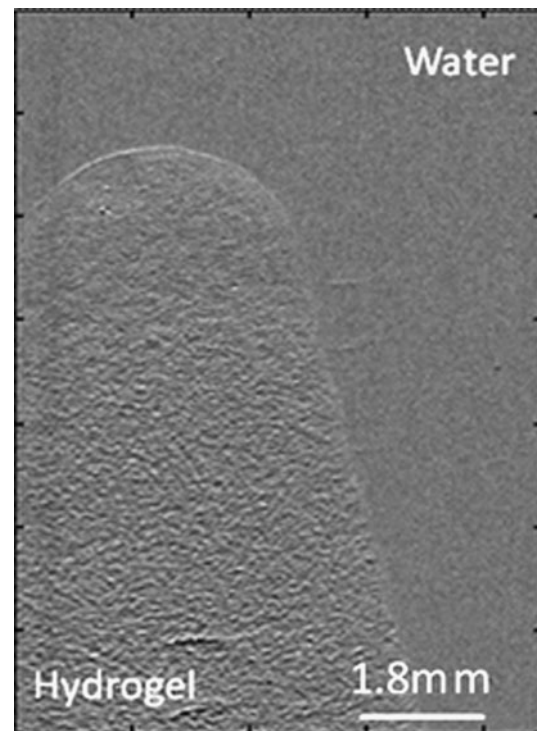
X-ray refraction images allow identification of porous PEG hydrogels in water. The speckle pattern observed is due to the multiple interactions of pores and X-rays as they pass through the sample. PEG, polyethylene glycol.
